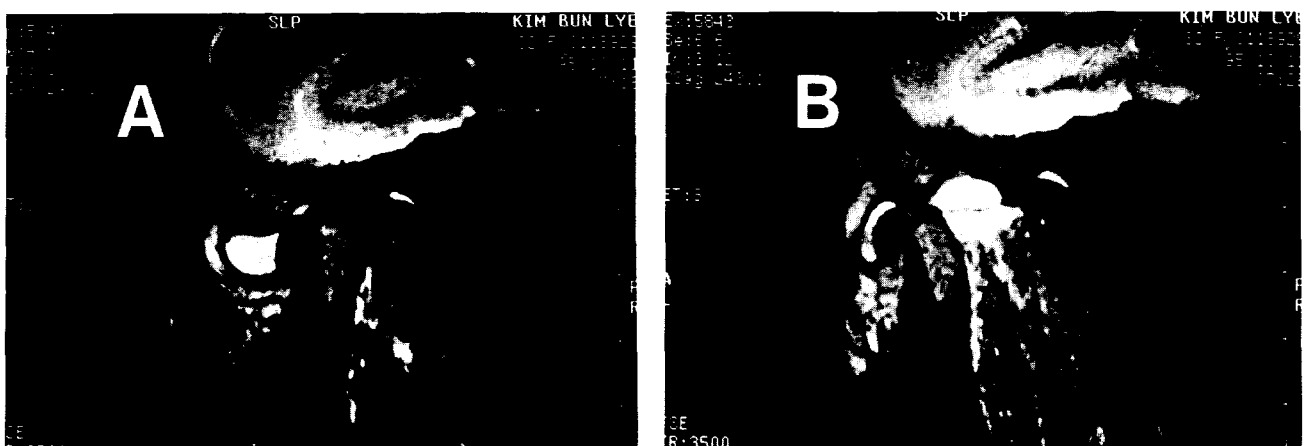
Joint effusion in closed (A) & open (B) mouth seen by T2-weighted sagittal MR image of anterior displacement without reduction of the temporomandibular joint in 32-years female.
